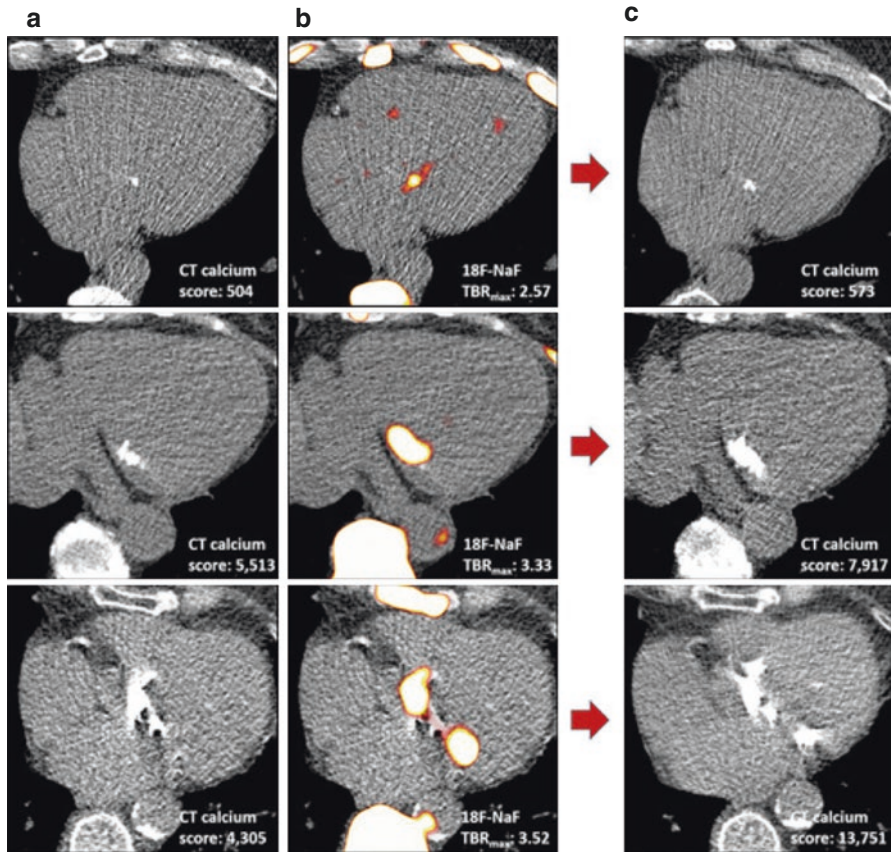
Baseline computed tomography mitral annular calcification (CT-MAC), ^{18}F -fluoride positron emission tomography (PET) activity, and 2-year progression in three patients. First row, mild MAC at baseline (a), associated with mild mitral annular ^{18}F -fluoride uptake (b) and modest progression after 2 years (change in CT-MAC 69 AU (c)). Second row, moderate MAC at baseline (a), moderate ^{18}F -fluoride uptake (b), and intermediate progression after 2 years (change in CT-MAC 2404 AU (c)). Third row, severe MAC at baseline (a), bifocal high-intensity ^{18}F -fluoride uptake (b), and rapid progression (change in CT-MAC 9446 AU (c)). Note de novo areas of MAC that developed at the site of intense ^{18}F -fluoride uptake in the lateral annulus. (Massera et al. [26])
